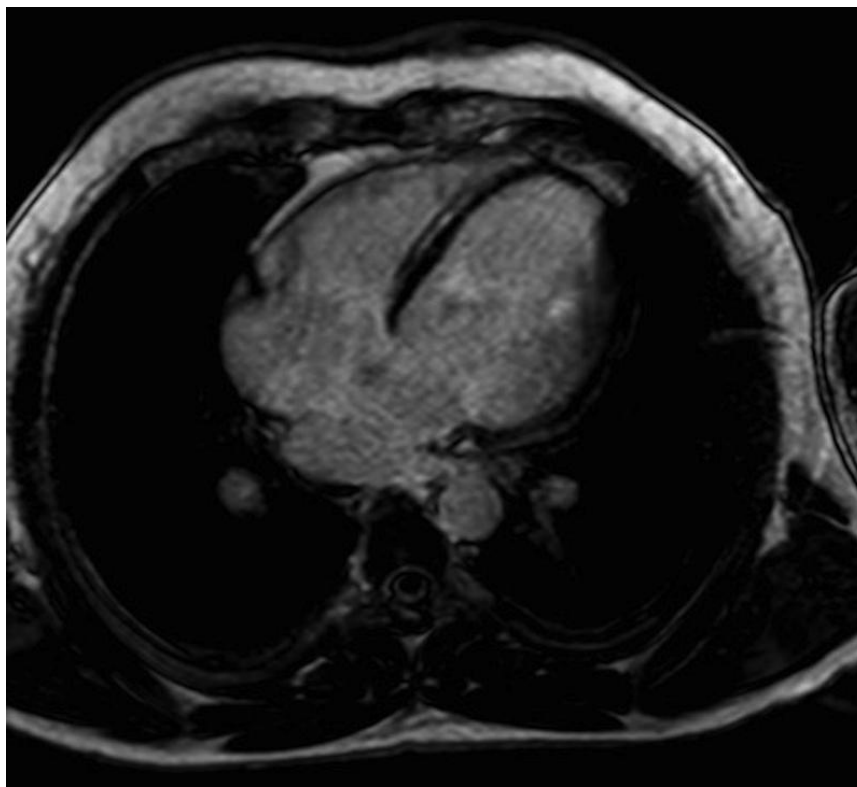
MRI of a patient with cardiac NIHF, 35% EF, and a mesocardiac area of fibrosis in the interventricular septum. MRI: magnetic resonance imaging; EF: ejection fraction.
